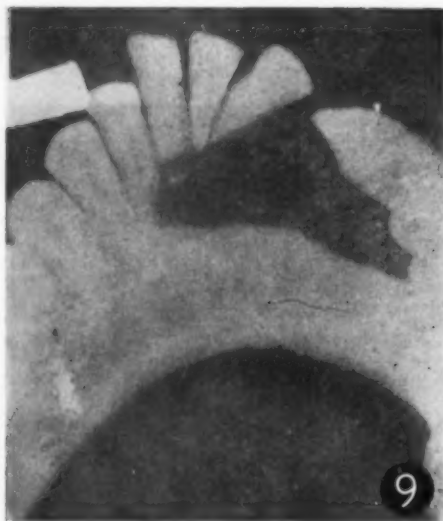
X-rays of adamantinoma.
